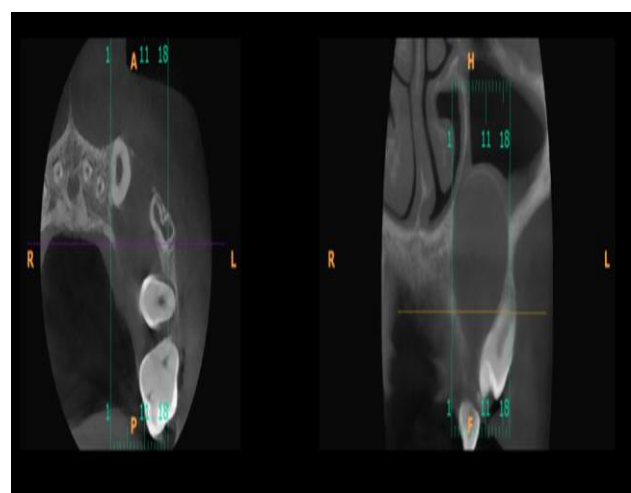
CBCT sagittal view showing superior displacement of the antral floor.
